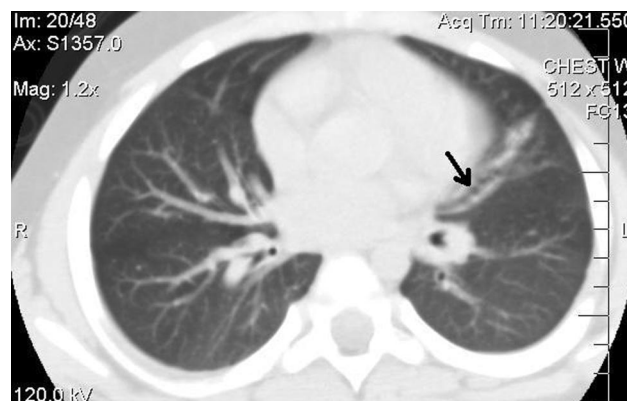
Computed tomography scan of the chest, demonstrating a focal area of varicose bronchiectasis (black arrow) in the left upper lobe.
